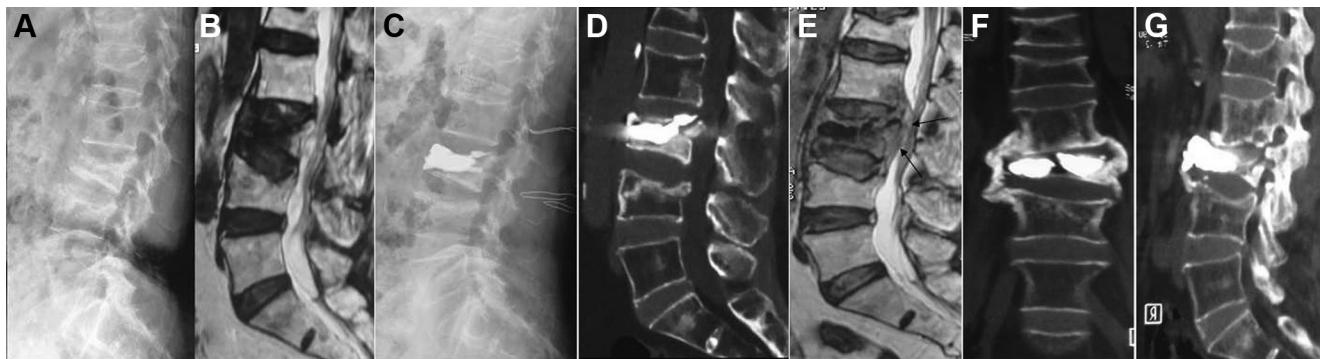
(A and B) Lateral radiographs and magnetic resonance imaging (MRI) of a 67-year-old woman indicated an acute vertebral compression fracture of L3. (C) Vertebral augmentation was performed at this level. (D and E) On readmission, computed tomography (CT) and MRI showed paradiscal signal changes at the L2–L3 level with a ventral intracanal collection of fluid and bony destruction (black arrow). (F and G) One year after the initial surgery, CT of the same patient revealed a favorable radiological outcome with fibroosseous healing at the L2–L3 level.
